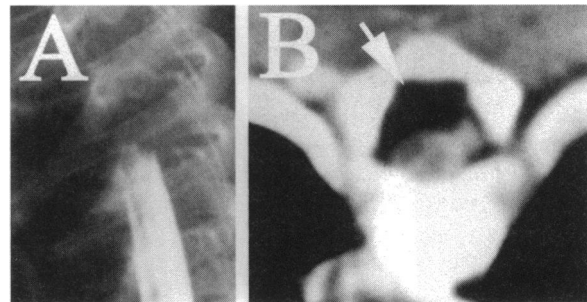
CT myelogram of Surgicel® compression (case 1) (A) Myelography shows a complete extradural block to contrast flow. (B) The axial CT indicates the significant size of the intraspinal mass (arrow).
